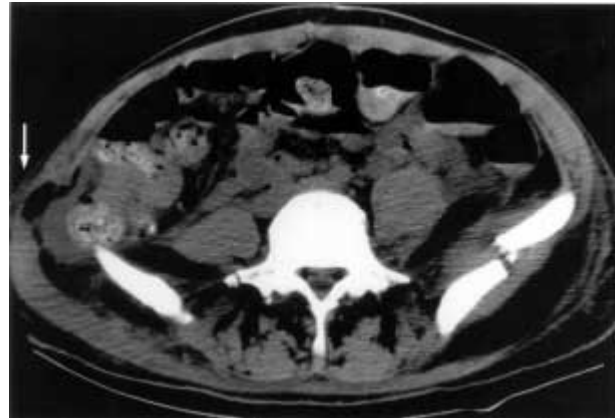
Original CT-scan showing the pelvic fracture, ipsilateral hematoma and the contralateral hernia (white arrow shows hernia).
